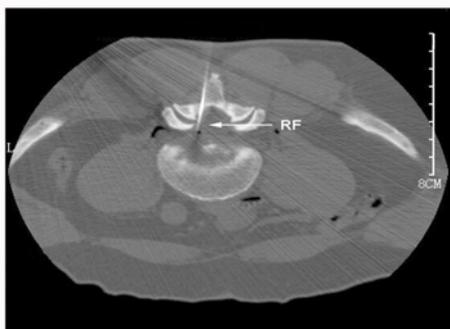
Intraoperative CT images of RF.
